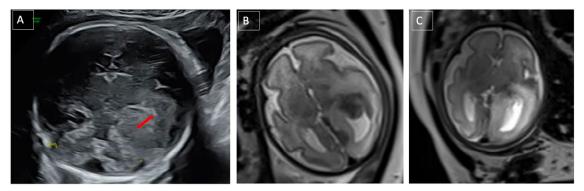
Ultrasound (US) at 30th week of gestation. Hyperechogenicity of the right temporo-occipital region (red arrow), with an erased gyration (A); antenatal Magnetic resonance imaging (T2, axial plane) at 30th WoG. Hyperintense and dedifferentiated aspect of the white-gray substance in temporo-occipital region with obliteration of the furrows at this level (B); Magnetic resonance imaging (T2, axial plane), at 34 WoG. Aggravation of the right hemispheric lesions (C).
